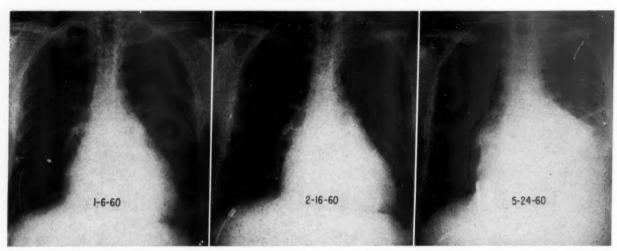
Representative chest roentgenograms. The roentgenogram on the left was obtained one week before insertion of first pacemaker wires. Worthy of notice is cardiomegaly with smooth contour. The center roentgenogram shows no appreciable diminution in cardiac size following one month of pacemaker stimulation at a normal rate. The roentgenogram on the right shows change commensurate with three left thoracotomies. The heart size has definitely increased and the right atrial contour is irregular.
